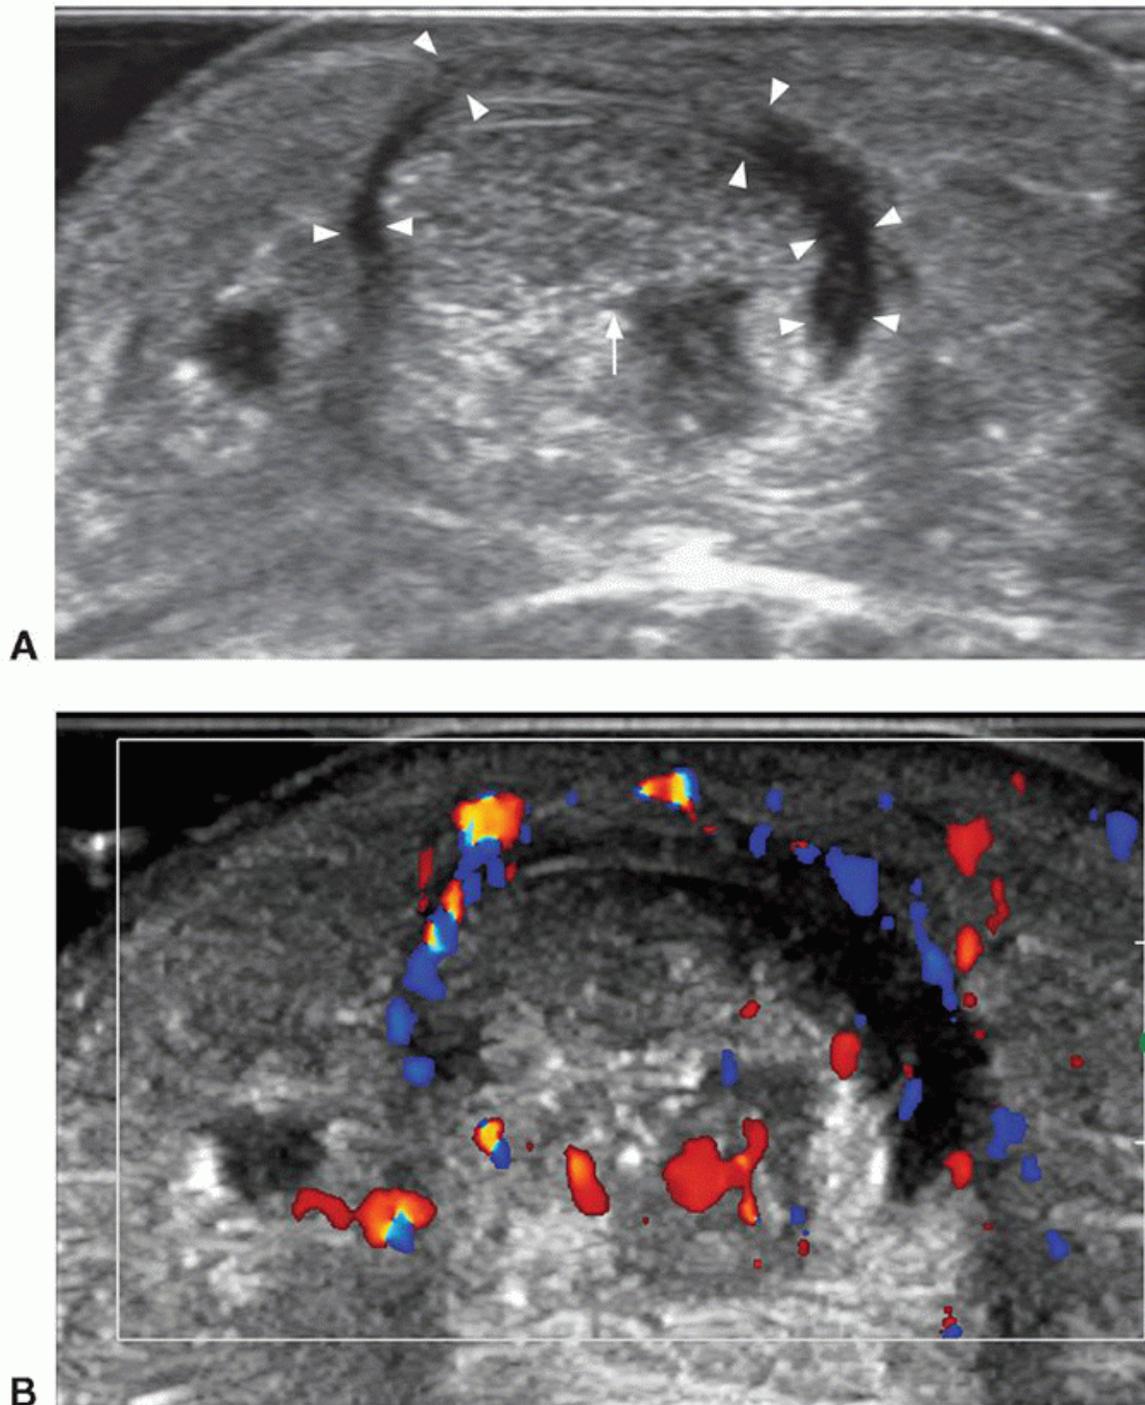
Transverse ultrasound of Achilles tendon (arrow) showing (A) a hypoechoic rim (arrowheads) around the sides and dorsal surface of the Achilles tendon due to a thickened paratenon. The Achilles tendon is normal. B: Color Doppler imaging shows a marked hyperemia around and, to a lesser degree, within this distended paratenon overall consistent with chronic paratenonitis.
